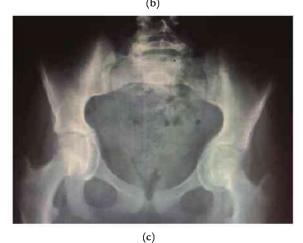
(a) X-ray of pelvis with both hips showing looser's zones. (b) X-ray of pelvis with both hips showing pathological fractures. (c) X-ray of pelvis with both hips showing triradiate pelvis.
